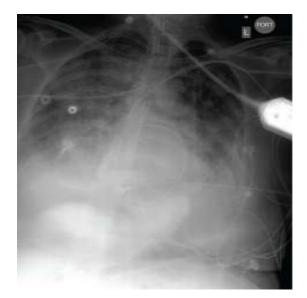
Chest X-ray of an ARDS Victim that suffered a grade 4SAH (Kahn et al, 2006)
